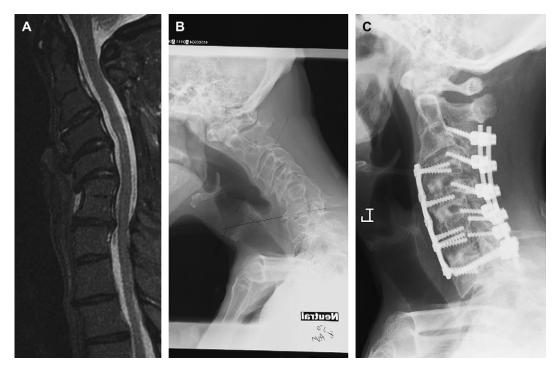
Sagittal MRI (A) and lateral radiograph (B) of a 60-year-old man with a prior laminectomy and Klippel-Feil malformation at C2-C3 shows progressive fixed kyphotic deformity. (C) Lateral postoperative radiograph after a three-staged procedure, including posterior release, C3-T1 posterior spinal fusion, and C3-T1 correction to anterior cervical discectomy and fusion, shows marked reduction of fixed deformity.
